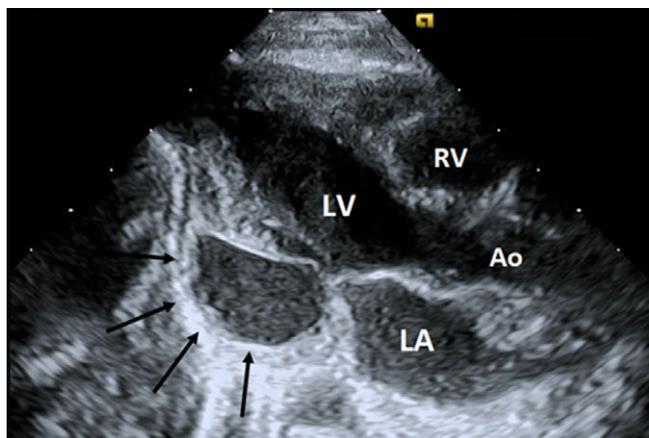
Parasternal long-axis image of a left ventricular aneurysm in a survivor of neonatal enteroviral myocarditis. The aneurysm is in the posterior basal LV (arrows) with myocardial wall thinning and paradoxical bulging of the aneurysm during ventricular systole. Ao = aorta; LA = left atrium; RV = right ventricle.
